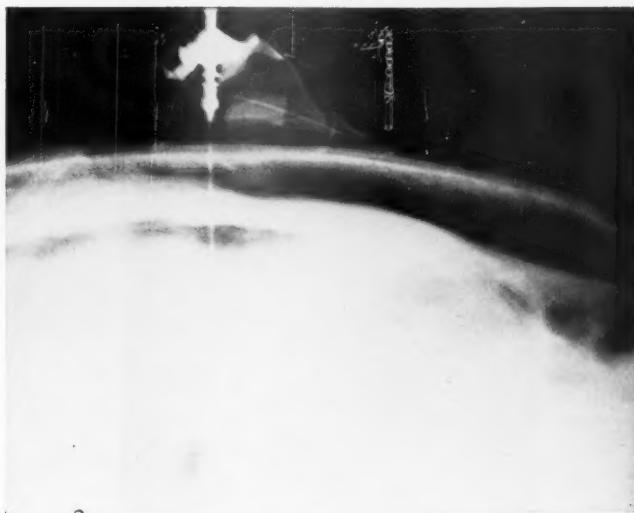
Right lateral recumbent chest x-ray (portable) after insertion of needle into right pleural space. The massive subcutaneous emphysema and the position of the needle in the right chest are demonstrated.
